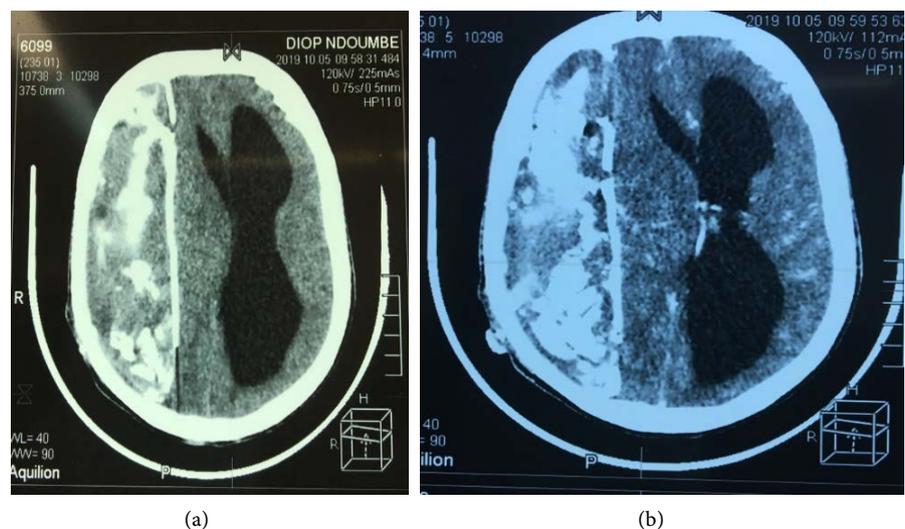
Preoperative without contrast CT scan (a) showing an isodense right hemispheric lesion with internal hyperdensity and midline shift with right hemisphere displacement (b).
